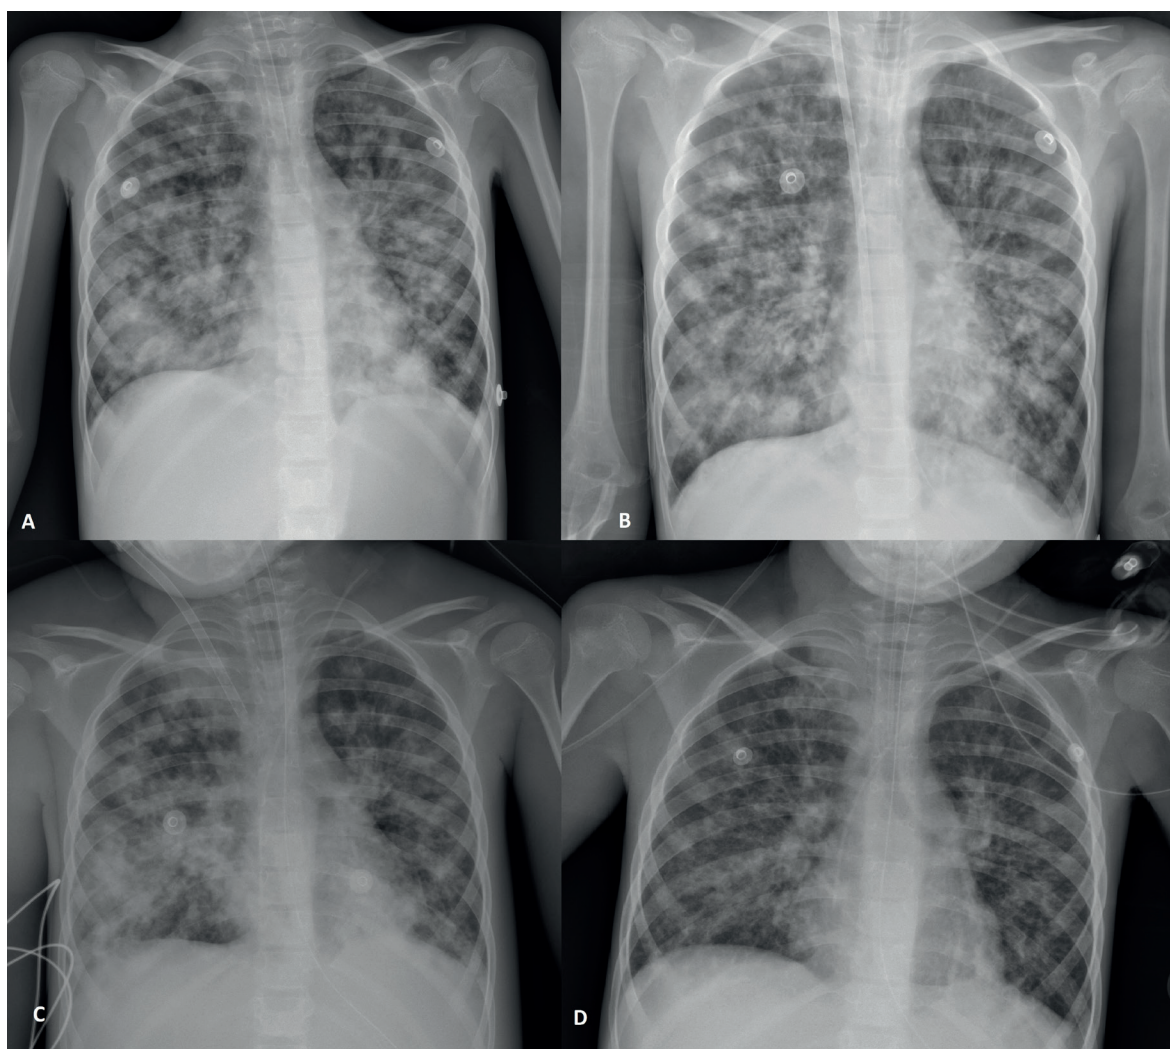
Chest X-ray images of the patient.
